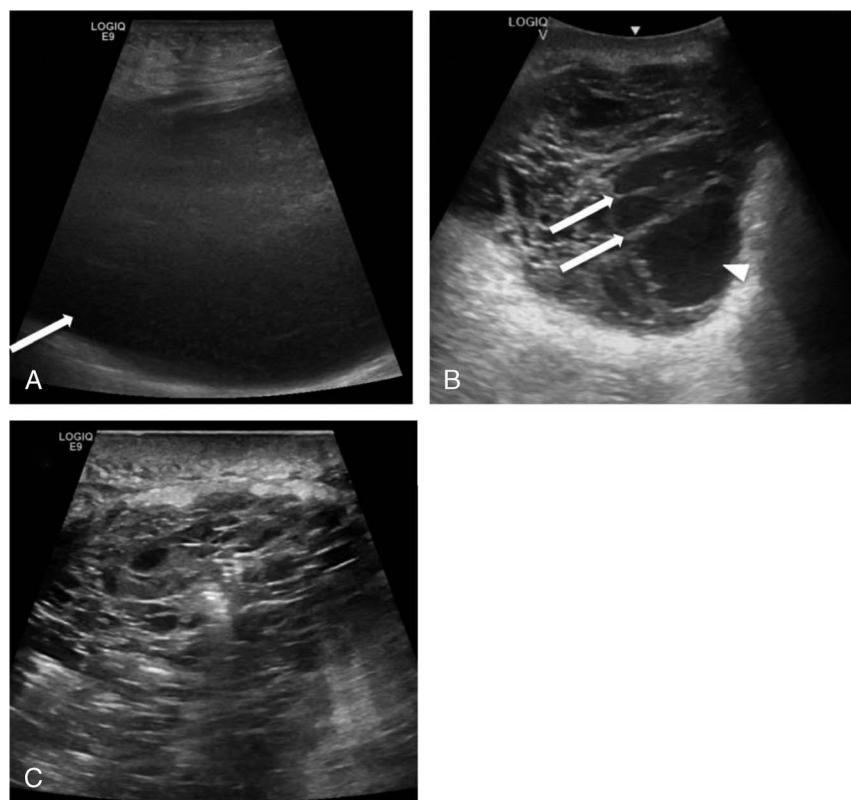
A 74-year-old man with metastatic malign melanoma and with a large symptomatic lymphocele after inguinal lymph node dissection. A, Ultrasound before the first ST shows a hypoechogenic collection (white arrow). B, Ultrasound after 2 ST with OK-432 displays multiple hyperechogenic septae (white arrow) but still some remnant collections (white arrowhead). C, After the third ST, the lymphocele has a honeycomb-like aspect. No more fluid could be drained, and the drain was removed.
